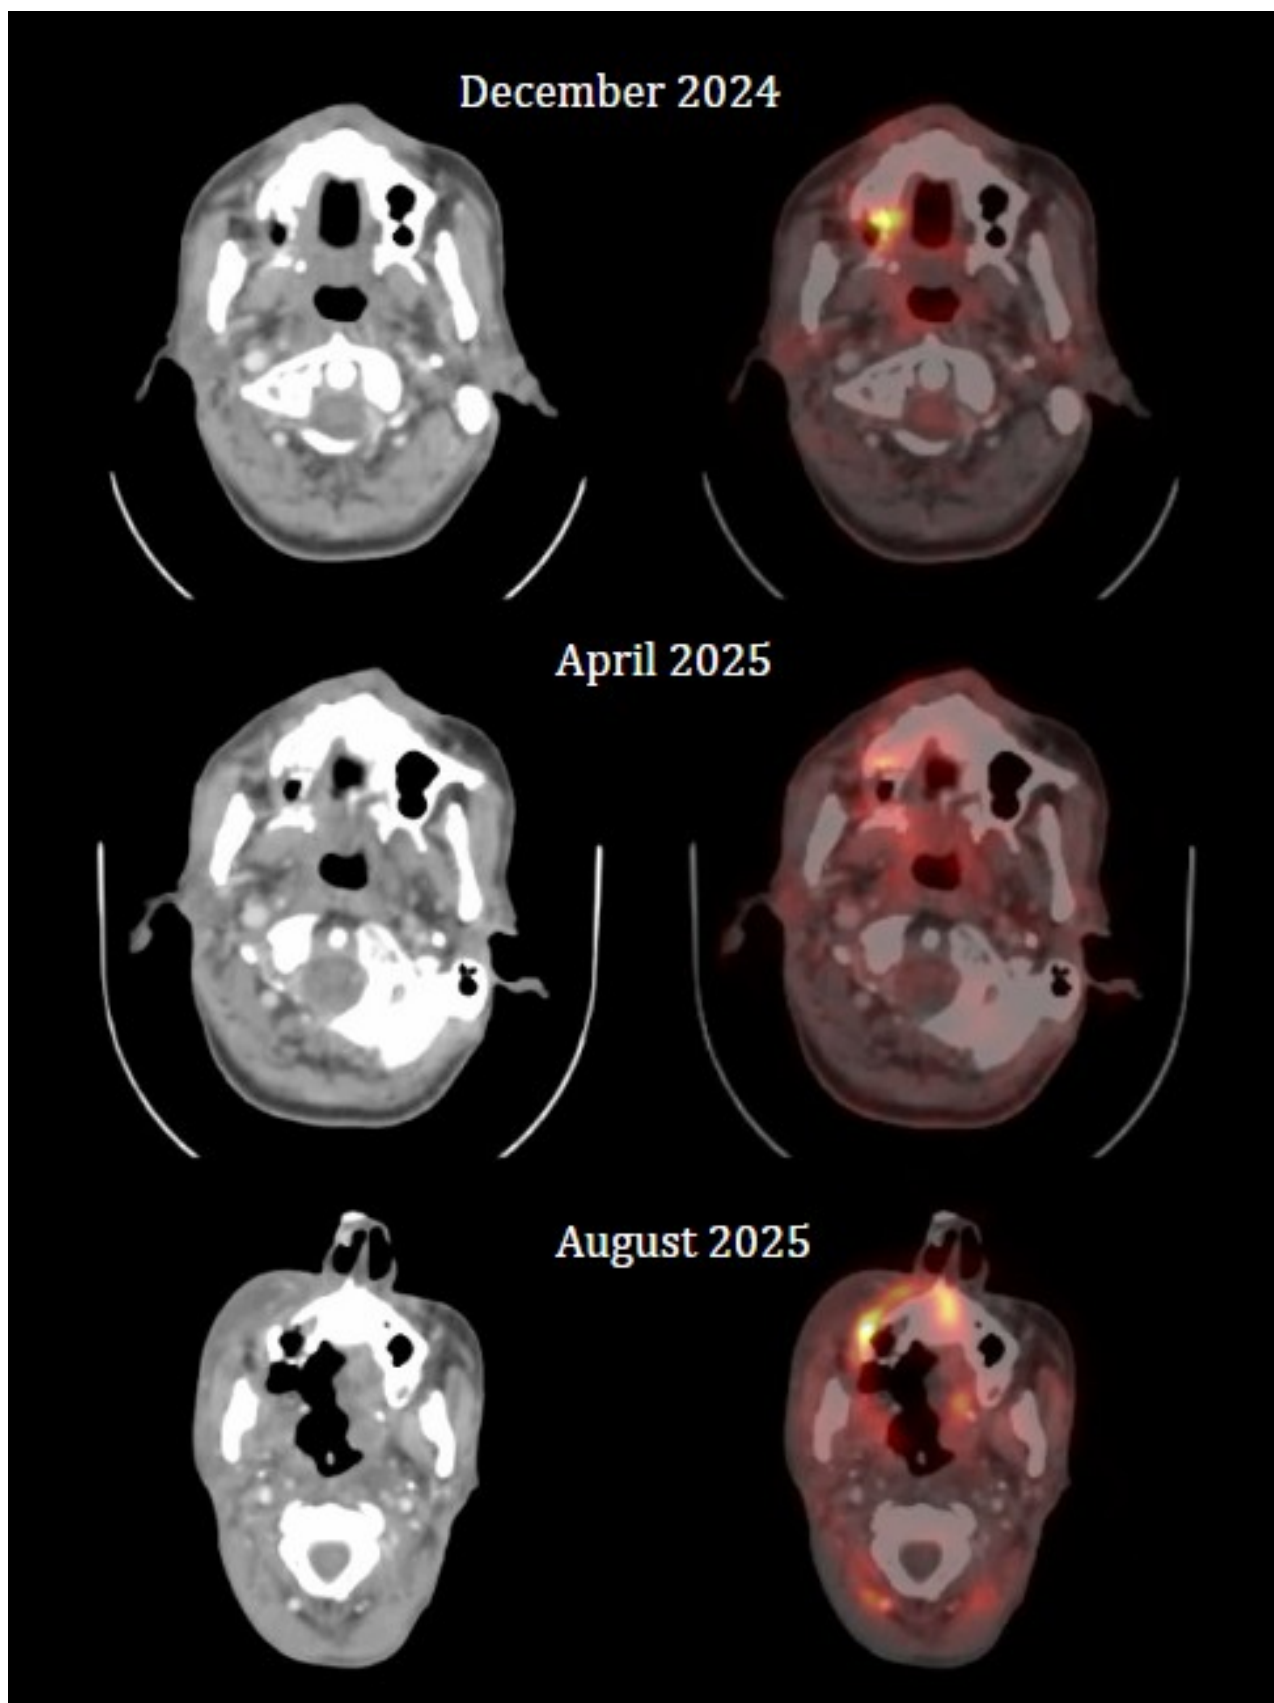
Axial CT and fused PET/CT images. The uppermost panel (December 2024) shows a lesion in the right tonsillar region with bony erosion along the right hard palate and maxillary alveolar process. The middle panel (April 2025) was reported as metabolically inactive. The lower panel (August 2025) demonstrates a destructive necrotic lesion centered in the right maxillary alveolar process, consistent with marked disease progression.
